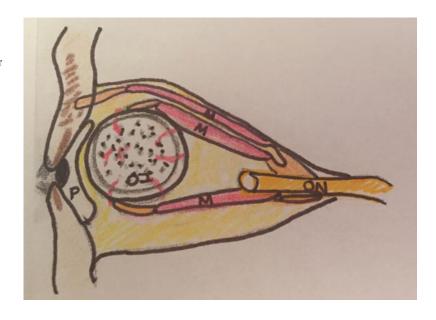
a Gross external photograph of non-salvageable ruptured left globe with remnants of cornea and sclera visible along lower eyelid following penetrating periocular trauma. b Axial CT of the orbits showing
